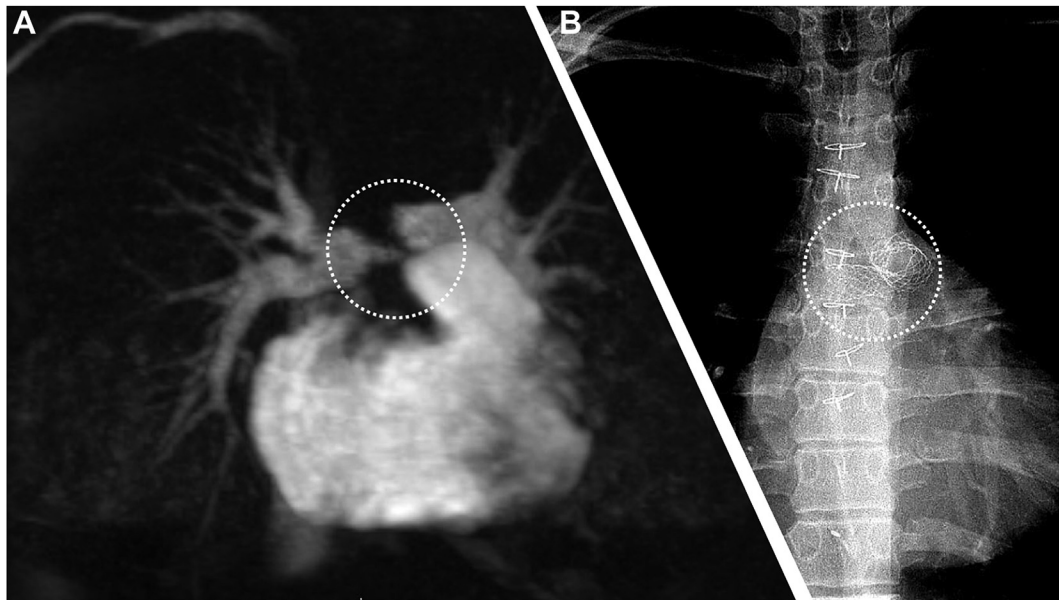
Effect of metal on visibility in CMR. Tetralogy patient with bilateral pulmonary artery stents. (A) Coronal MR dynamic angiogram in the pulmonary arterial phase. Note the odd appearance of both central pulmonary artery ostia (dotted circle). These do not look like typical stenoses, and the suspicion should be that the appearances are artefactual. (B) This is confirmed on plain CXR (shown here with the mediastinum sharpened for clarity), where bilateral PA stents (dotted circle) are visible. Metal usually causes local signal void on CMR. There is no good way around this, and cardiac CT was required in this case to confirm stent patency. CMR, cardiac magnetic resonance; CT, computed tomography; CXR, chest x-ray; MR, magnetic resonance; PA, pulmonary artery.
